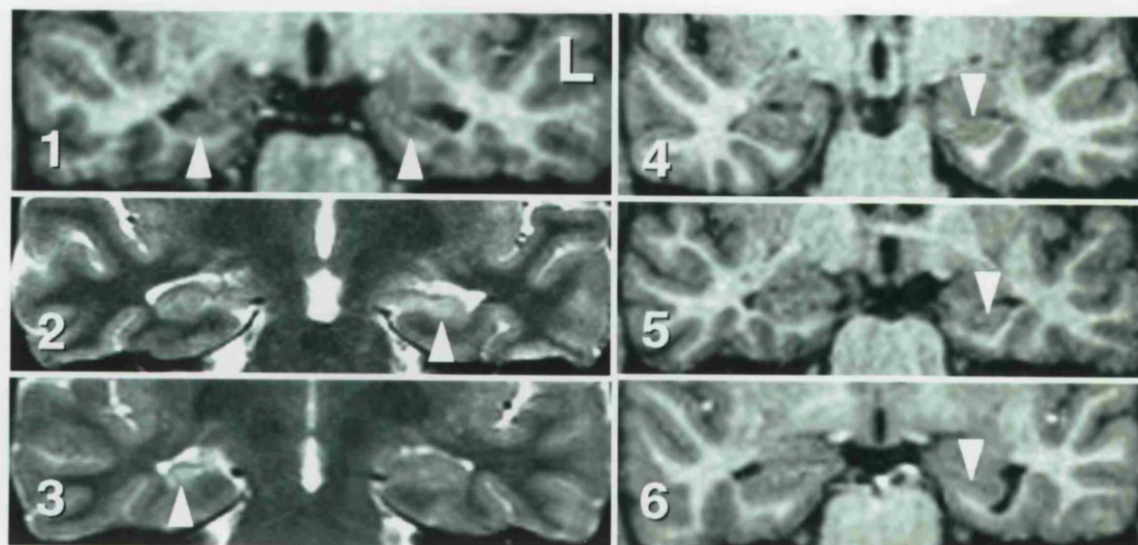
HS in adults with newly diagnosed localization-related epilepsy. Involved hippocampi are indicated by white arrows. 1, 4-6: reformatted MPRAGE images, 2 and 3: T2-weighted images (TE = 80 msec). Median HCVR of these 6 patients was 0.77 (range: 0.67 to 0.82). Normal values: HCVR \geq 0.87, HCV $>$ 3932 mm³, HCT2 \leq 111 msec. 1. Bilateral diffuse hippocampal atrophy with normal HCT2s (*see also Figure 44, p 157*) (HCV left = 3446 mm³ and HCV right = 2802 mm³) with normal HCT2s (HCT2 right = 105 msec, HCT2 left = 108 msec) [Hospital number: QSC24608]. 2. Left diffuse hippocampal atrophy with increased HCT2 (HCT2 left = 119 msec, HCV left = 3901 mm³). 3. Right diffuse hippocampal atrophy with increased HCT2 (HCT2 right = 120 msec, HCV right = 3616 mm³) [Hospital number: QSC27812]. 4. Diffuse left hippocampal atrophy with normal HCT2 (HCT2 left = 104 msec, HCV left = 3772 mm³) and posterior atrophy of right hippocampus (not shown). 5 and 6. Left anterior hippocampal atrophy with normal HCT2 (patient 5: HCT2 left = 107 msec, HCV left = 4101 mm³; patient 6: HCT2 left = 108 msec, HCV left = 4423 mm³) [Hospital number: QSC26386]. Hippocampal atrophy in these last two cases only affected the head of the hippocampus i.e. at the level of the amygdala.
